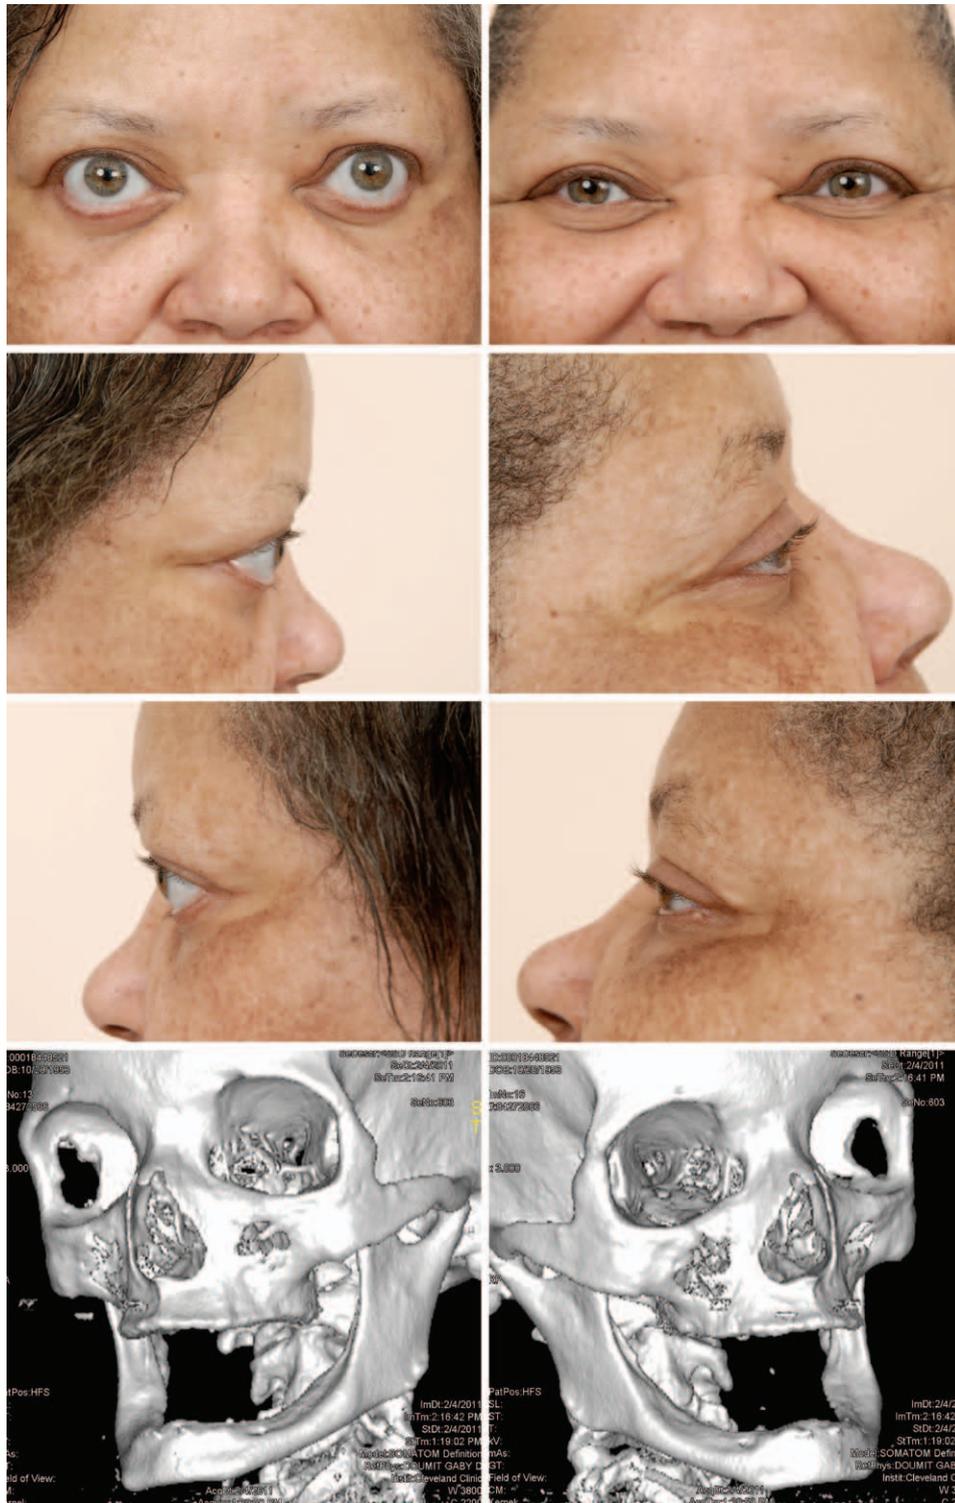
Case 1. A 57-year-old woman presented with bilateral dry eyes, epiphora, and progressive prominent eyes. The patient's medical history is positive for Graves disease and unrepaired left orbital floor fracture. Preoperative and 12-month postoperative Hertel exophthalmometer measurements were 25 mm (right eye) and 24 mm (left eye), and 20 mm (right eye) and 19 mm (left eye), respectively. (Above, left and second and third rows, left) Preoperative frontal and profile views. (Above, right and second row and third rows, right) Twelve-month postoperative frontal and profile views. (Below) Postoperative three-dimensional computed tomographic scans demonstrating the orbital wall decompressions.
